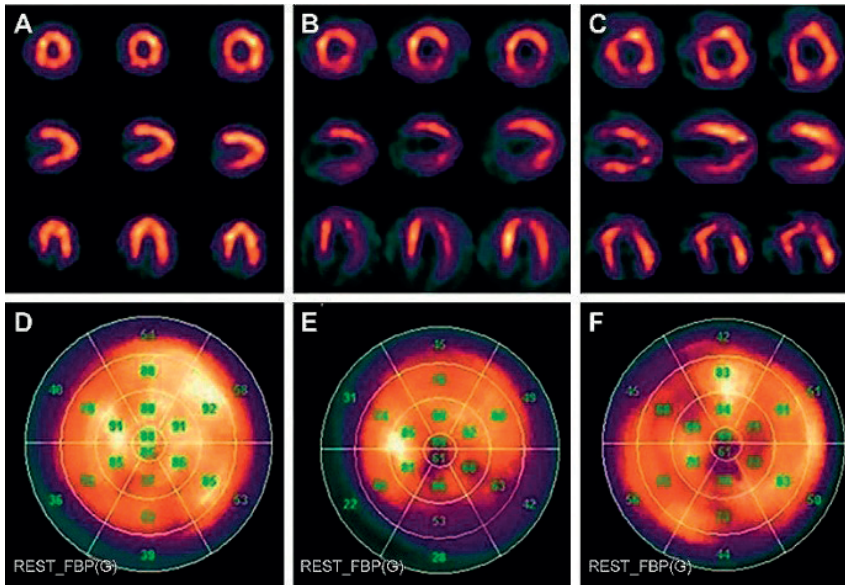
Myocardial perfusion defects at rest assessed with ^{99m}Tc single-photon emission computed tomography in three patients with Duchenne muscular dystrophy. Cross-sectional myocardial perfusion images are displayed in A-C panels (short-axis, horizontal long-axis and the vertical long axis from top to bottom) and the polar maps are presented in panels D-F. The patient presented in panels A and D shows normal myocardial perfusion whereas the patients in panels B/E and C/F show perfusion defects in the inferior and apical segments. REST_FBP: filtered back projection images acquired at rest, (G): gated. Reproduced with permission from Zhang et al.⁸
